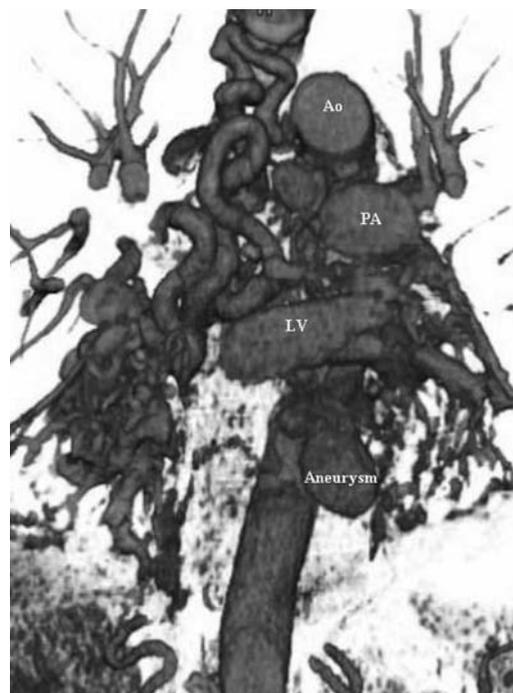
Three-dimensional reformation of CT angiogram with volume-rendering technique revealed an aneurysm of a bronchial artery arising from the aorta.
